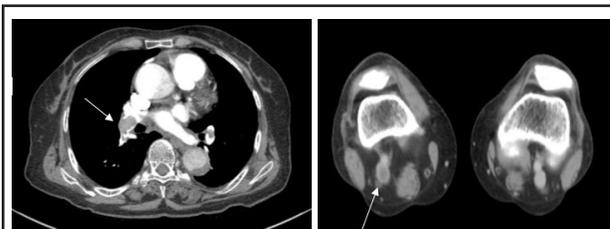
CT angiography showing emboli in both pulmonary arteries and deep vein thrombosis in the right lower leg (white arrows).
